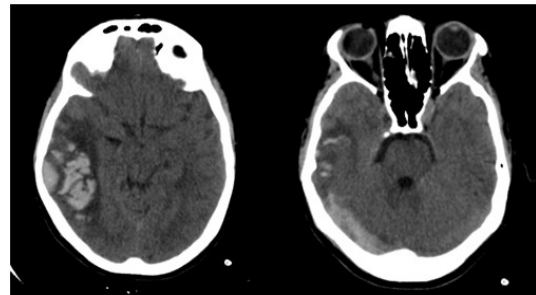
25 year old female at postpartum day 5 c/o 1 episode of seizure Non contrast CT revealed atypical hemorrhage in right temporal lobe. Thrombosed right transverse sinus is seen.
